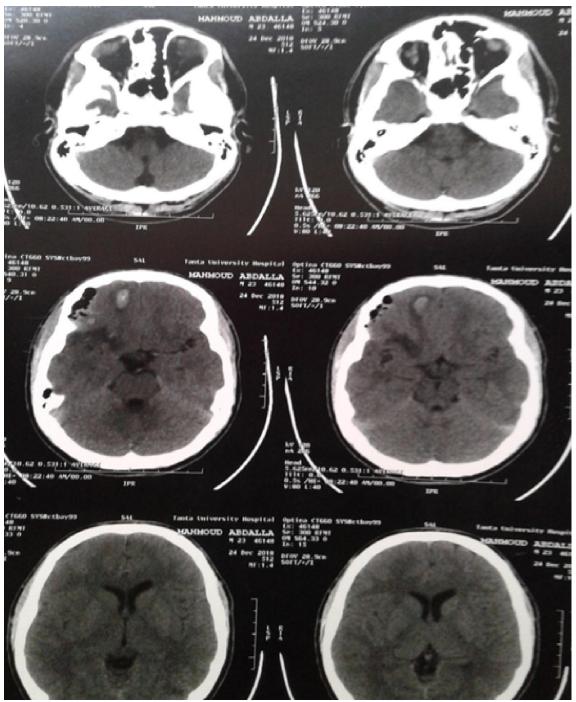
CT brain of case 3 after 48 hours.
